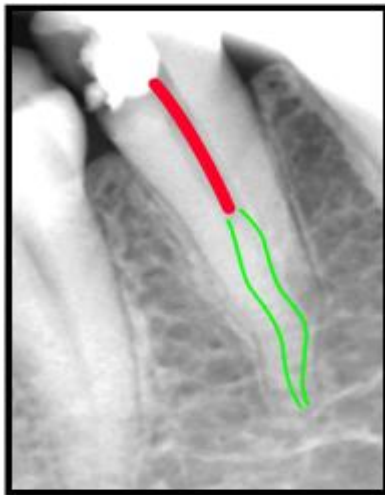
Pre-operative radiograph of #44 showing unusual canal configuration
